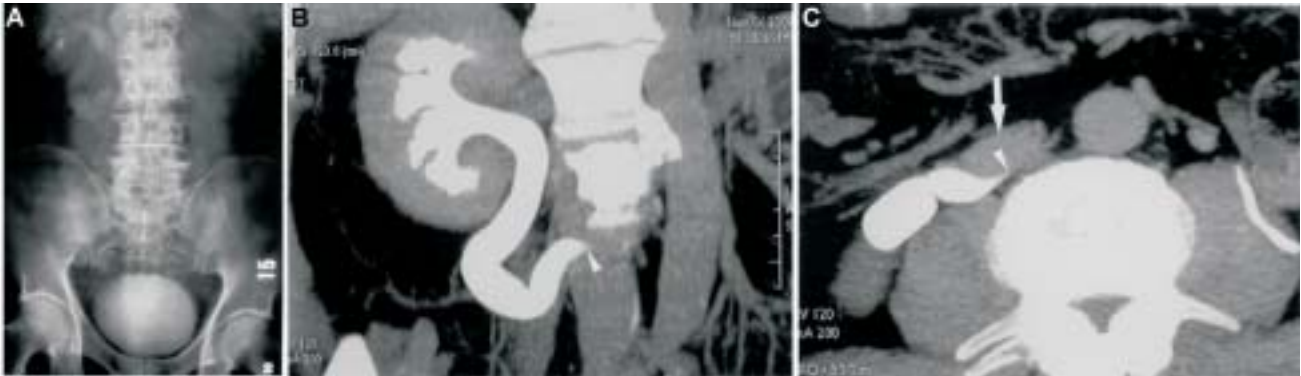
A 48-year-old man with clinical presentation of right flank pain. (A) IVU shows moderate hydronephrosis and hydroureter of the right side with the presence of a tortuous right ureter. (B, C) Post-contrast CT and reformatted CT urography show the same findings of IVU, however, bird beak-like narrowing at the upper third of the right ureter (arrowheads), which is compressed by IVC (arrow), is clearly demonstrated. Retrocaval ureter was diagnosed.
